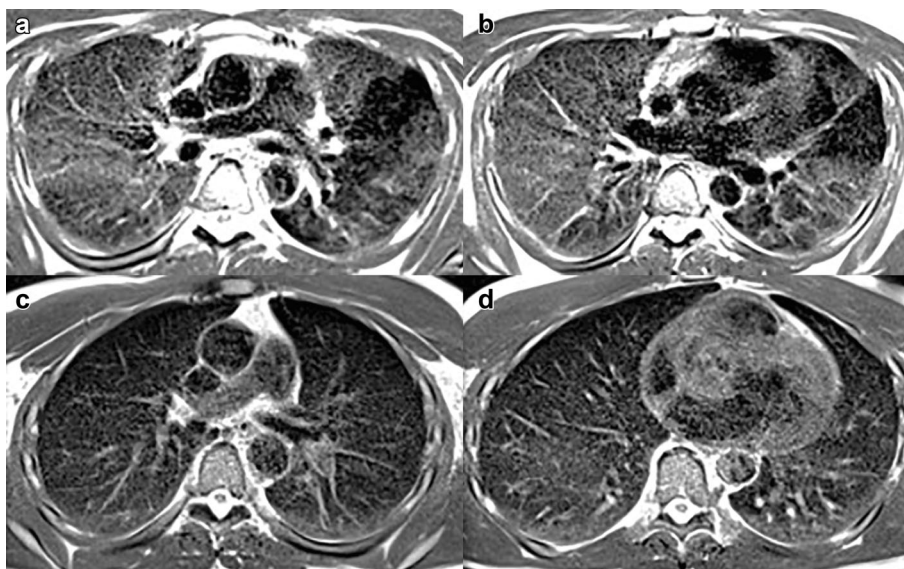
(a, b) Asymptomatic patient. T2-weighted axial images through the lungs show diffuse bilateral lung opacities and total opacity score of 12; only portions of the lingula and anteromedial basilar left lower lobe are spared. The patient had a respiratory incoherence measure of 0.0202; values closer to 0 indicate more regular breathing. (c, d) Severely symptomatic patient. T2-weighted axial images through the lungs show no appreciable pulmonary opacity (total opacity score of 2 likely representing dependent atelectasis). The patient had a relatively high respiratory incoherence value of 0.0474, signifying a departure from a regular breathing pattern.
